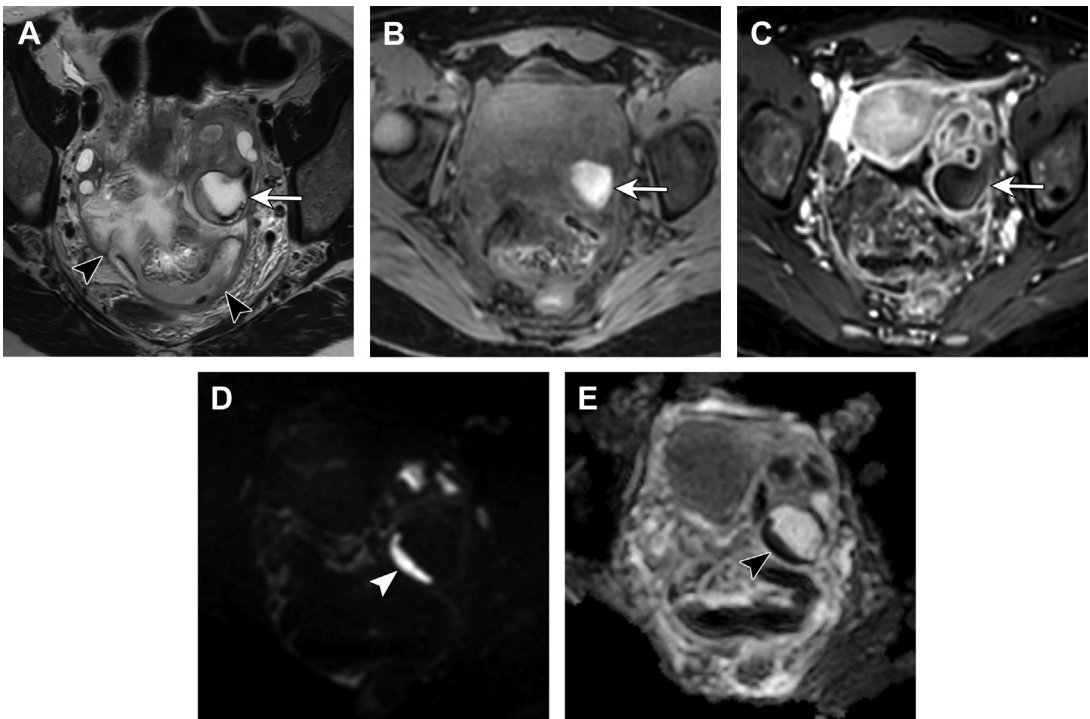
Left tubo-ovarian abscess. Short axis oblique T2-weighted MR image (A) shows an enlarged left ovary with diffuse, mild increased signal intensity of the ovarian stroma and a cystic component (*white arrow*). Inflammatory peritoneal thickening (*black arrowheads*) and heterogeneous ascites are also present. Axial T1-weighted image with fat saturation (B) shows hyperintense signal within the left ovarian cystic structure (*white arrow*). Axial subtraction post-contrast T1-weighted image with fat saturation (C) shows rim enhancement of multiple locules, including the cystic structure (*white arrow*). Axial diffusion weighted image (b-value = 1600) (D) shows markedly hyperintense signal within the cystic component (*white arrowhead*). Axial apparent diffusion coefficient map (E) shows corresponding hypointensity of the cystic component which restricts diffusion (*black arrowhead*).
